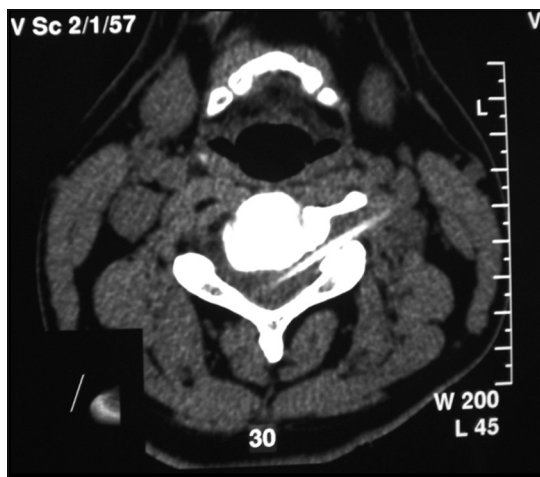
Computed tomography scan showing entrance of the thorn through left C3-C4 foramen
